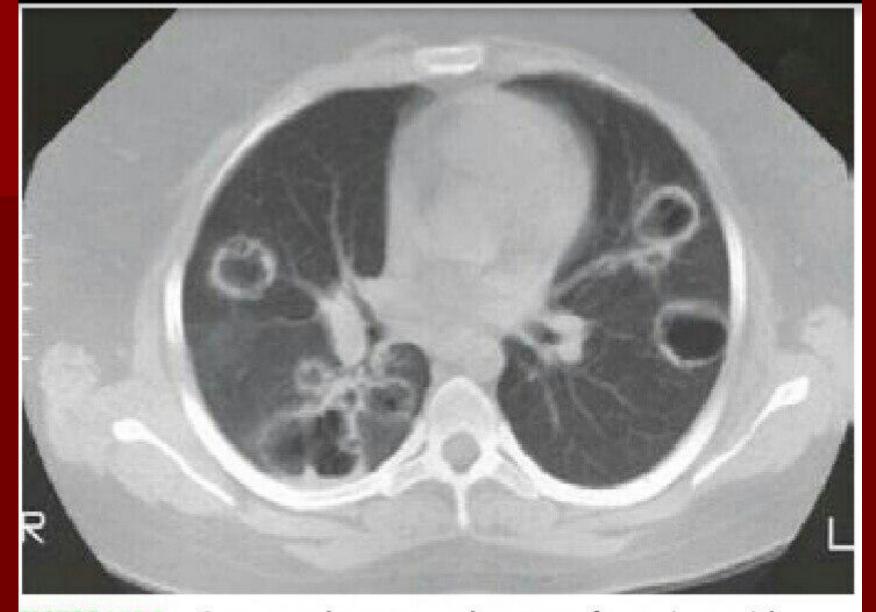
Computed tomography scan of a patient with granulomatosis with polyangiitis (Wegener's). The patient developed multiple, bilateral, and cavitary infiltrates.
